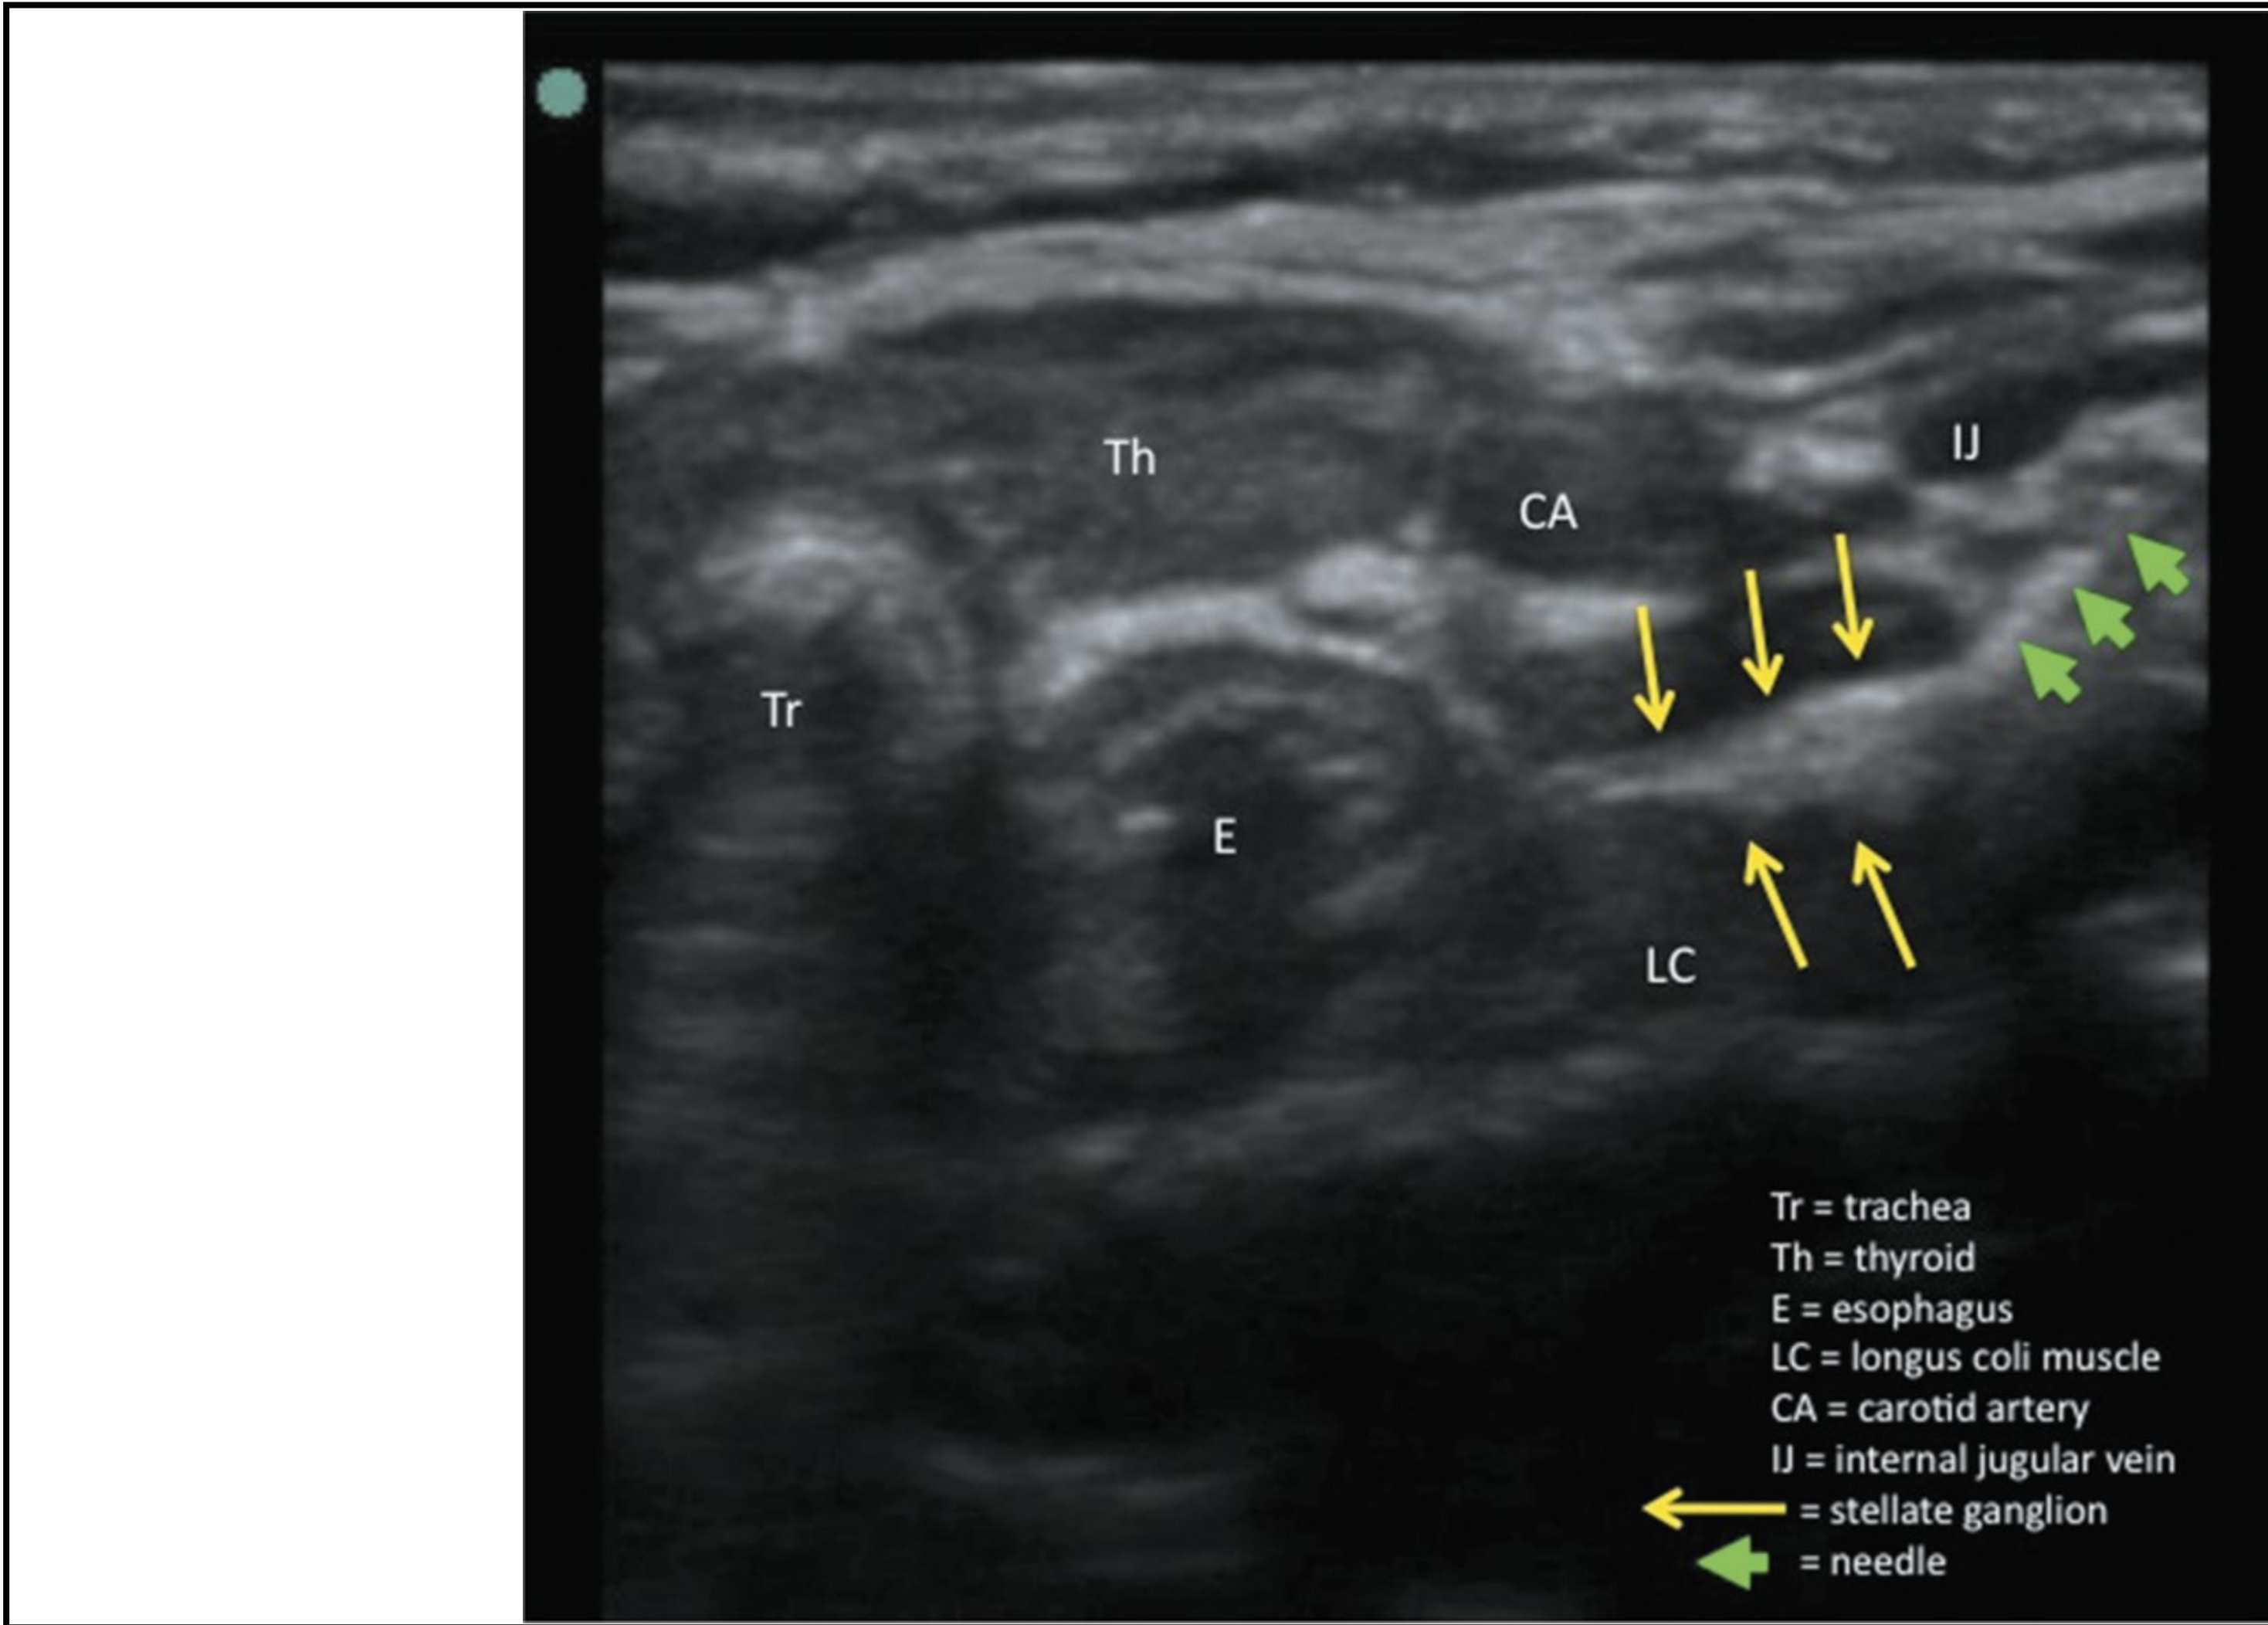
Ultrasound image of SGB. Transverse cervical view demonstrating key anatomical landmarks: thyroid (Th), trachea (Tr), esophagus (E), carotid artery (CA), internal jugular vein (IJ), and longus colli muscle (LC). Yellow arrows indicate the stellate ganglion target adjacent to the longus colli, with green arrow showing in-plane needle advancement technique.⁵
